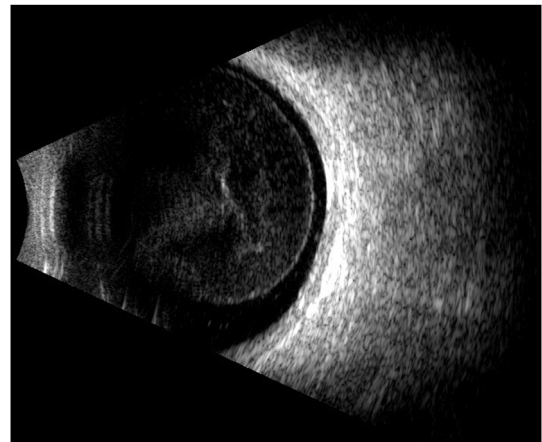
Vitreous and sub-hyaloid opacities OS – This ultrasound image shows the dense vitreous opacities and sub-hyaloid opacities of the left eye secondary to nivolumab use.
